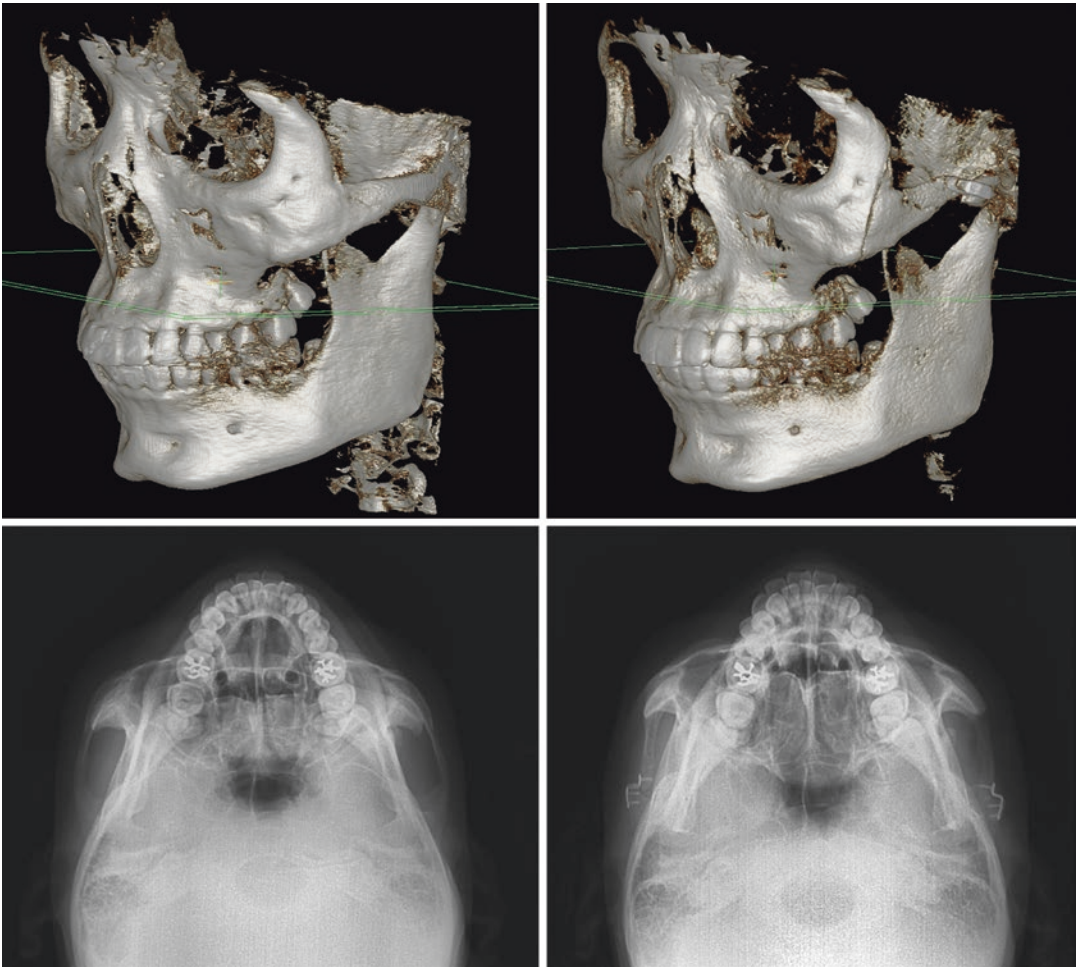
Comparison on preoperative and postoperative imaging studies. Preoperative and postoperative three-dimensional computed tomographic images (*above*).
